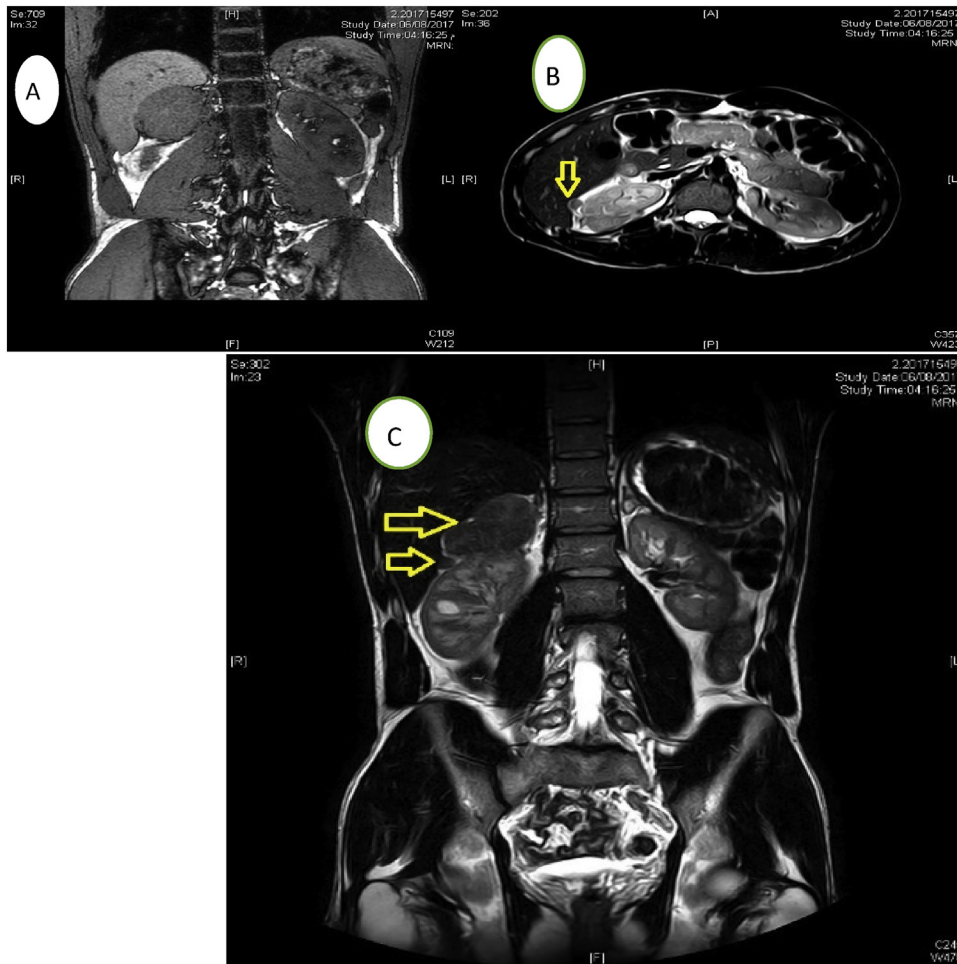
(A) MRI reformatting image showing right supra renal mass measuring about 9.4×7.8 cm. (B) Extra hepatic peritoneal focal lesion related to lateral aspect of segment VI of the liver measured $2.5 \times 2 \times 1$ cm. (C) Reformatting image of MRI showing both lesions.
